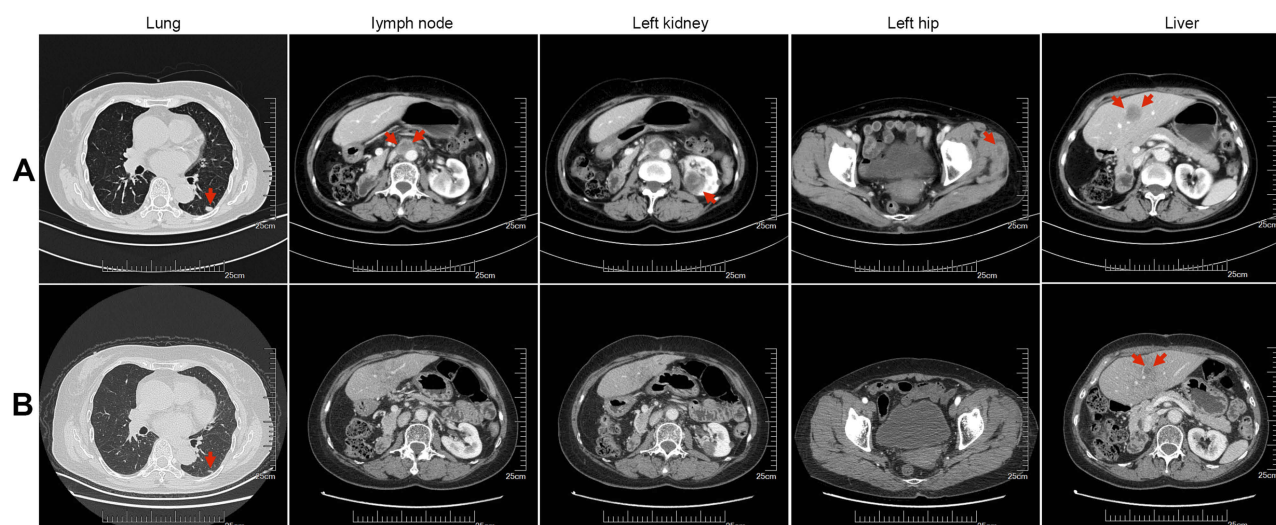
Computed tomography scan shows different lesions in lung, lymph node, left kidney, liver, and left hip during immunotherapy. (A) Lesions before immunotherapy are indicated by arrows. (B) Lesions after immunotherapy are indicated by arrows.
